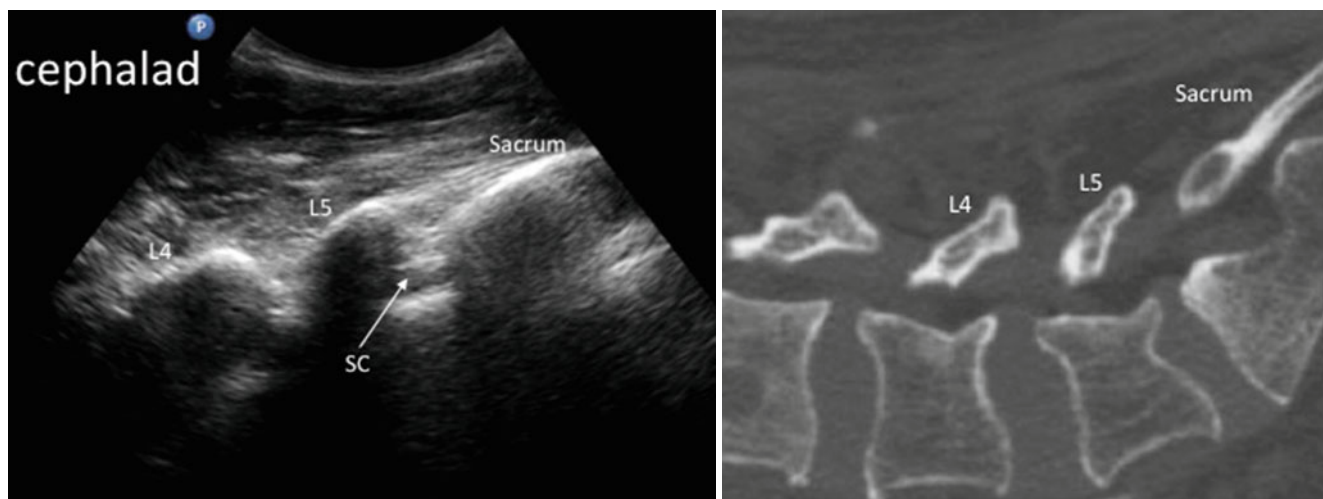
Parasagittal oblique ultrasound view of the spine at the lumbosacral junction on the left and the corresponding magnetic resonance image on the right. SC spinal canal (Reproduced with permission from Philip Peng Educational Series)
